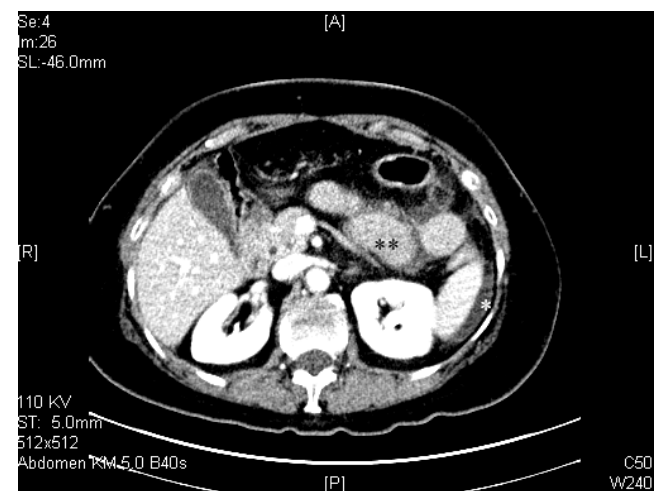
CT abdomen at the site of the later discovered jejunal rupture, showing free fluid around the spleen and a slightly distended jejunum.
